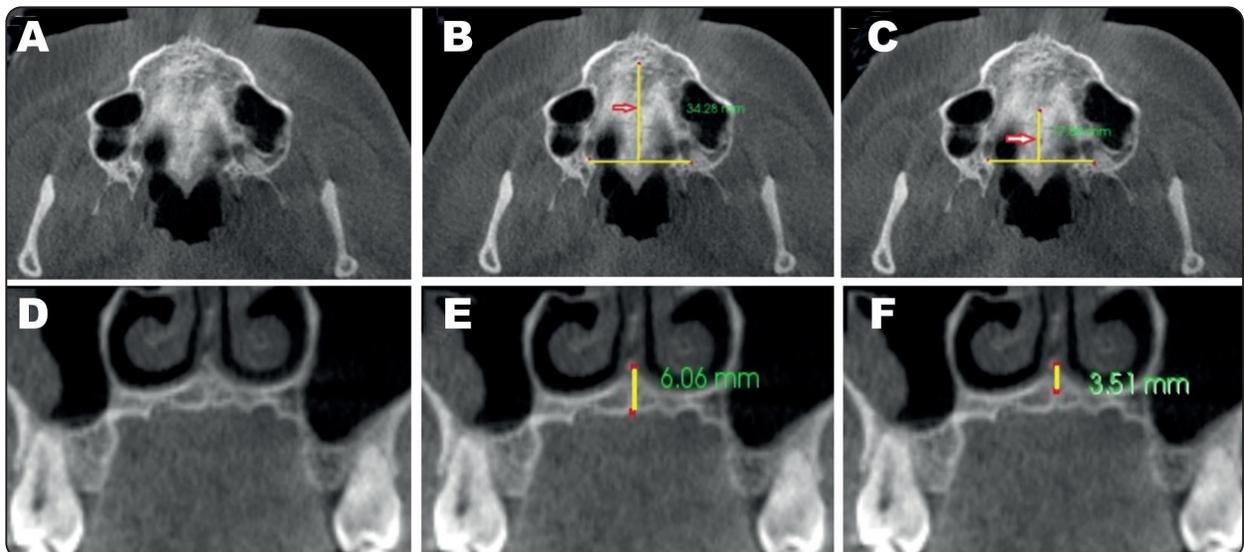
Axial CBCT images (A, B, C) revealing MPS horizontal obliteration index assessment. (A) Partially obliterated MPS, (B) Total MPS length along the line indicated by the arrow, and (C) The length of the obliterated part of the MPS along the line indicated by the arrow. Coronal CBCT images (D, E, F) revealing MPS vertical obliteration index assessment. (D) Partially obliterated MPS, (E) Total MPS length, and (F) The length of the obliterated part of the MPS.
